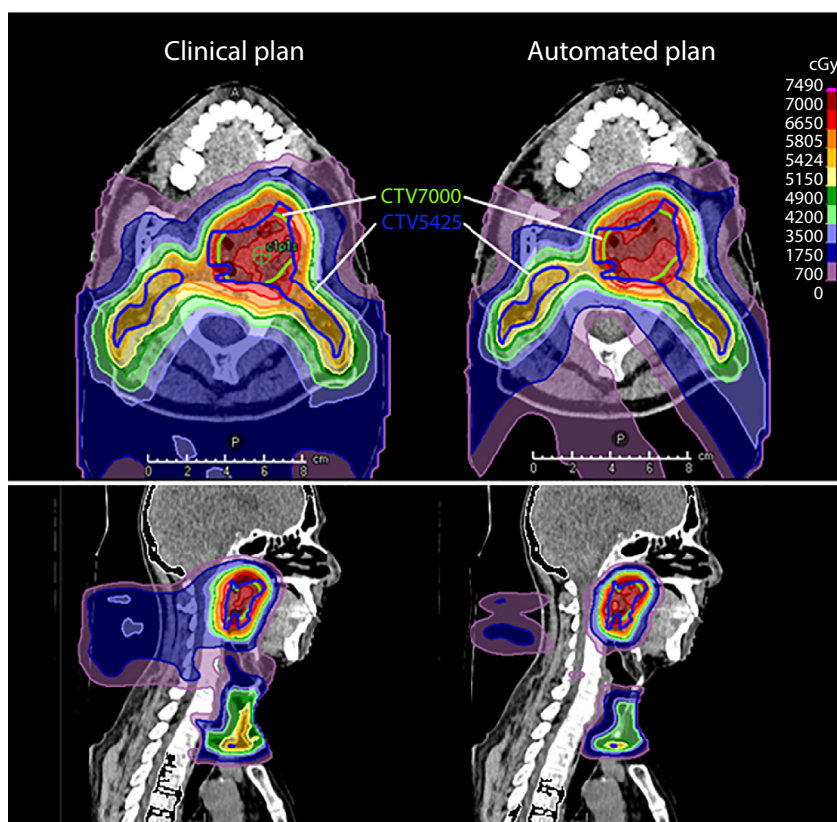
Transversal (top row) and sagittal cross-sections (bottom row) of a computed tomography with the nominal dose distribution of a clinical plan (left) and an automated plan (right) of 1 representative patient (patient 30). Note that in the automated plan, the isodose lines conform better to the targets with less dose to the surrounding healthy tissues.
